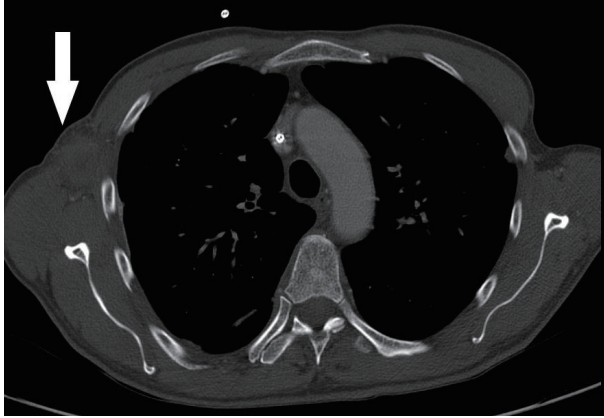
Chest contrast computed tomography findings (white arrow). 5 cm × 3 cm × 2 cm mass indicative of sparganosis in the right axillary area.
